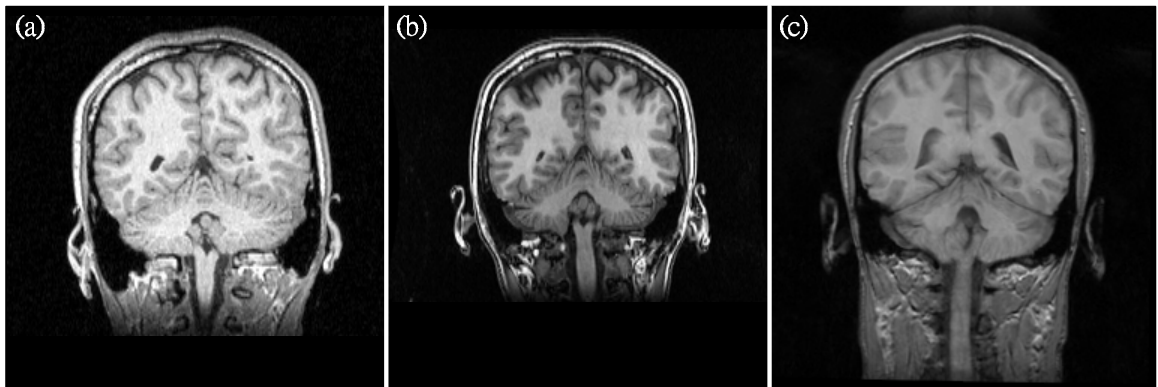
T1-weighted MR images acquired from different scanners present quite different intensity properties. MR images (a), (b), and (c) were scanned on a Bruker MedSpec S300 3T system, GE Signa EXCITE 1.5T system, and Siemens Magnetom 1.5T system, respectively.
